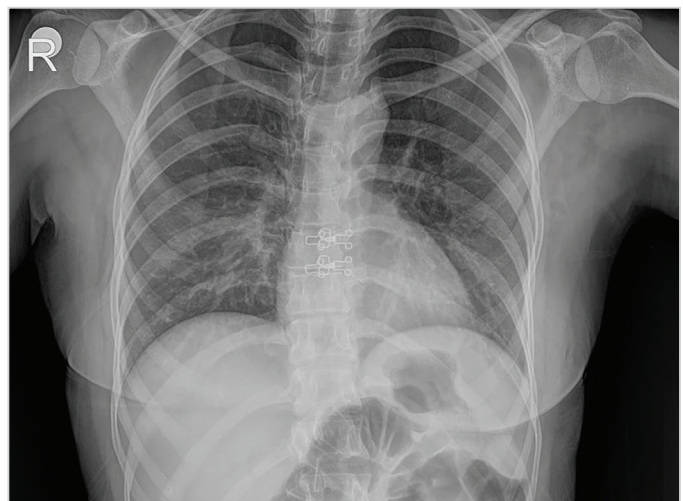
No significant pathology observed in the chest on posteroanterior chest radiograph
